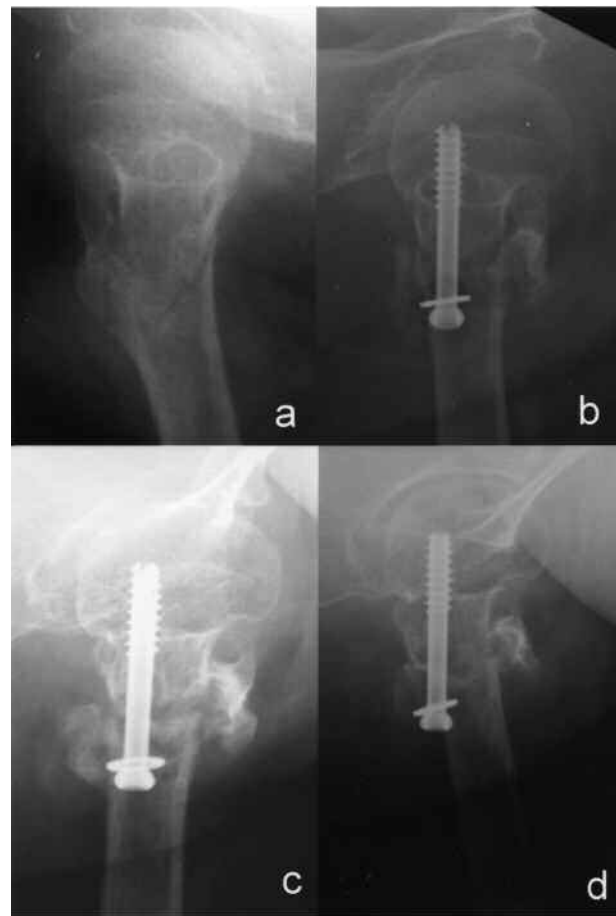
(a) Preoperation roentgenogram showing complete basal neck fracture. (b) One month after operation, showing callus formation. (c) Three months after operation, the amount and density of callus had increased. (d) Six months after operation, callus was consolidated and the fracture line is scarcely visible.
